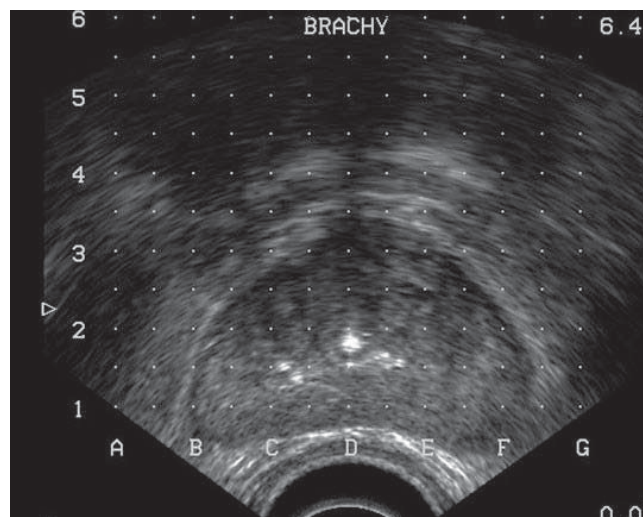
Axial ultrasonic image of the prostate with catheter in situ defining the position of the urethra (arrow).
